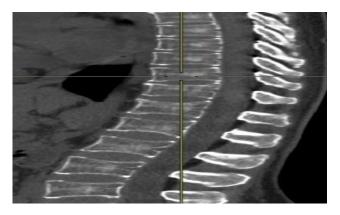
A CT scan of the thoracic and lumbar spine in case 1.
